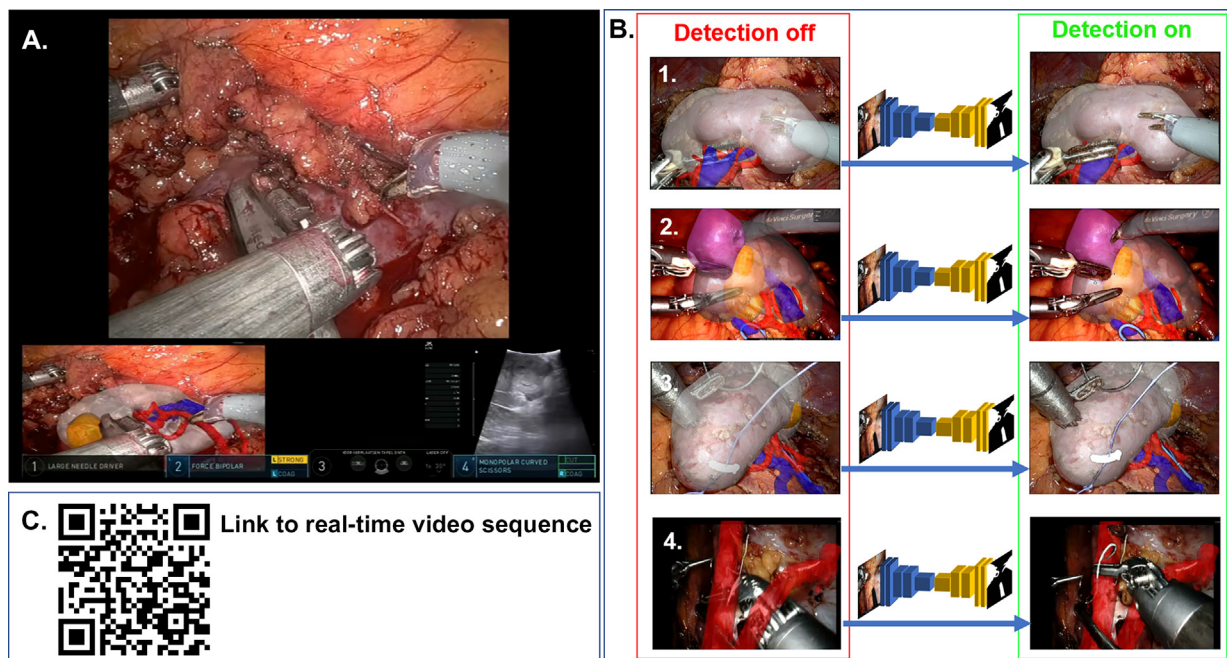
Real-time examples of augmented reality instrument detection (AR-ID). (A) The robotic console during surgery shows delineation of the monopolar curved scissors, force bipolar forceps, and ultrasound probe on top of the 3D model projection in the left TilePro window, while the right TilePro window shows the echography image during scanning across the tumor. (B) Four different cases of the greater visualization when detection is toggled on, namely, (1) precision of instrument detection in robot-assisted partial nephrectomy; (2) palpation of cysts and visualization of the underlying tumor is improved in AR, with detection of the vessel loop; (3) detection of wires, needles, Hem-o-lok clips, and vessel loops; and (4) integral transfers of the technology to robot-assisted kidney transplantation during arterial anastomosis, with detection of the robotic instruments and the sutures and bulldog clamps applied. (C) A QR code with a link to a video showing the on-off toggling of the AR-ID technology in different cases.
